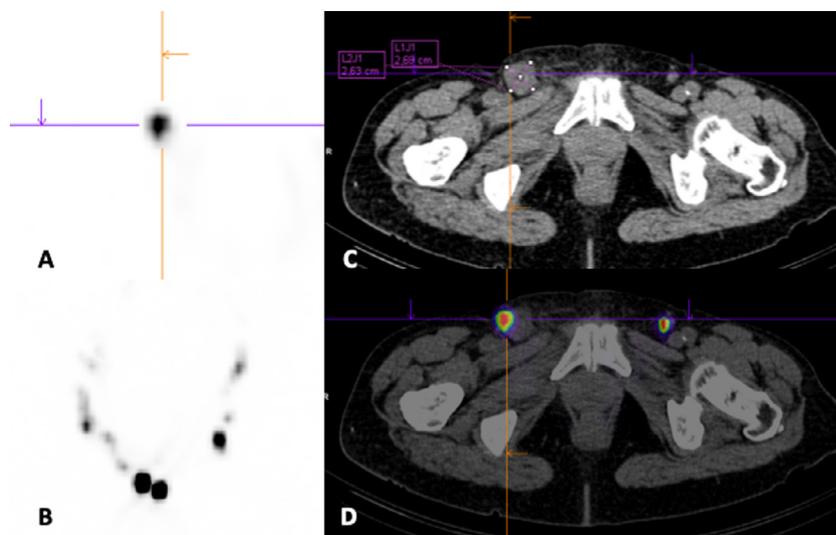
An 83-year-old woman, before surgery for vulvar melanoma, underwent sentinel LN scintigraphy. After injection of about 40 MBq of ^{99m}Tc nanocolloid in two peritumoral sites, planar images and SPECT/CT were acquired (A-axial view of SPECT, B-MIP, C-axial view of CT, D-axial view of fusion). Several focal uptakes were observed in SPECT/CT, noteworthy the right inguinal sentinel LN was measured 27×26 mm and was highly suspect for metastatic dissemination, it was confirmed at pathology, while two left millimetric inguinal LNs were not metastasized.
